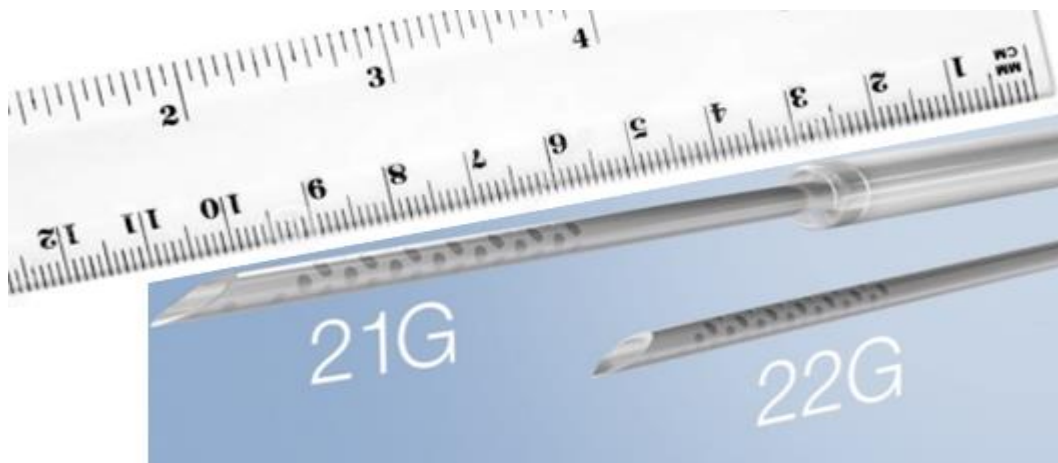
21G and 22G Olympus Vizishot needle tips. The spots visible on the needles are echogenic features on ultrasound. Copyright 2020 by Olympus America
